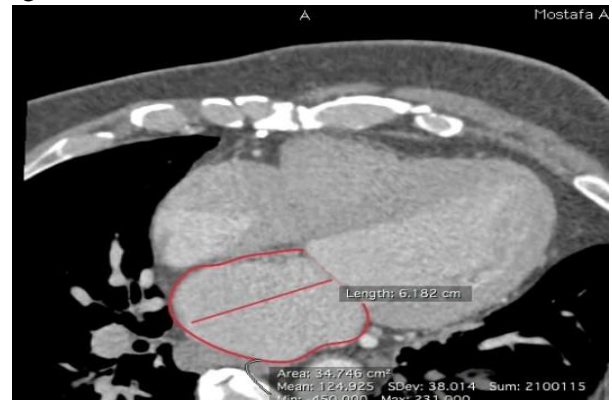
Showing Left atrial volume measured by multi-detector computed tomography by using three-dimensional reconstructed images and modified axial images.
